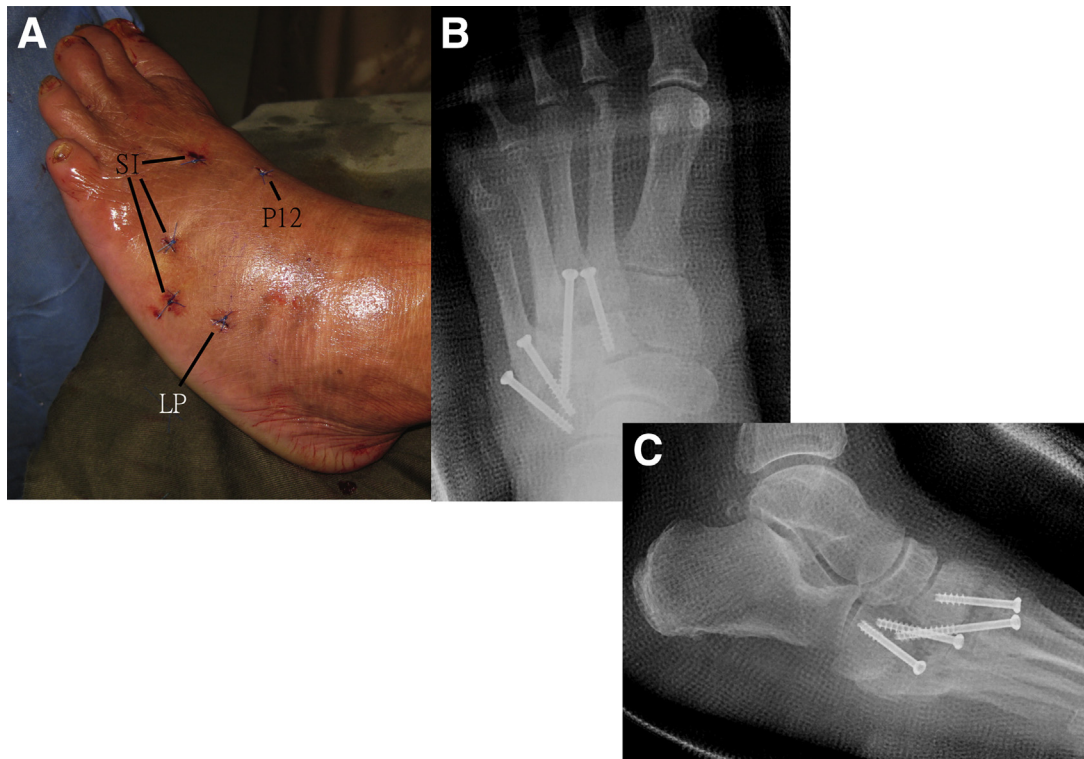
Arthroscopic arthrodesis of the lesser ray tarsometatarsal joints of the left foot. The patient is in the supine position. (A) The portals and screw insertion wounds are closed with simple sutures. (B) Dorsoplantar radiograph shows the second to fifth tarsometatarsal joints transfixed with screws. (C) Lateral radiograph shows the correction of the midfoot deformity. (LP, lateral portal; P12, P1-2 portal; SI, screw insertion wounds.)
